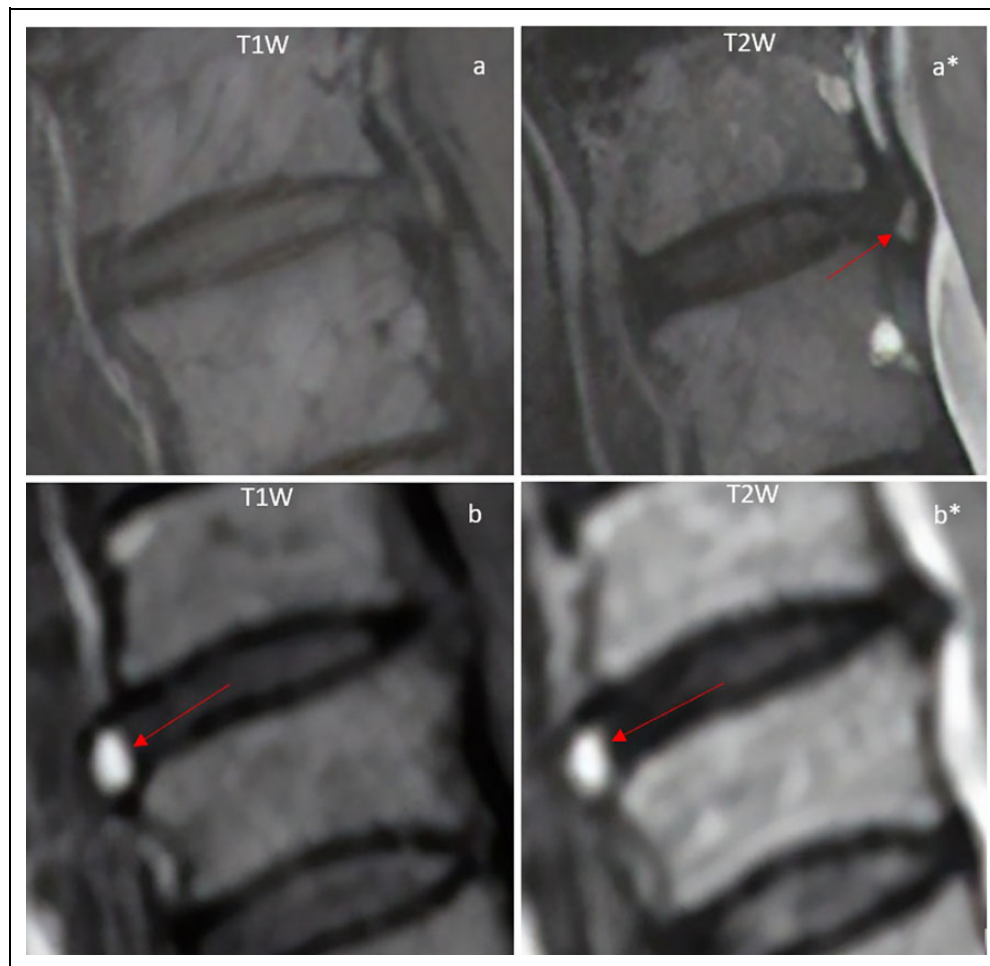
T1- and T2-weighted images of single- and dual-HIZ subtypes. (a, a*) T1-weighted image (left) without evidence of a HIZ, and corresponding T2-weighted image (right) with a single-HIZ in the posterior annulus of C5-C6 (arrow). (b, b*) T1-weighted image (left) showing the distinct morphology and intensity of a dual-HIZ in the anterior annulus of C6-C7 (arrow), with corresponding T2-weighted image (right) depicting a similar lesion (arrow).
